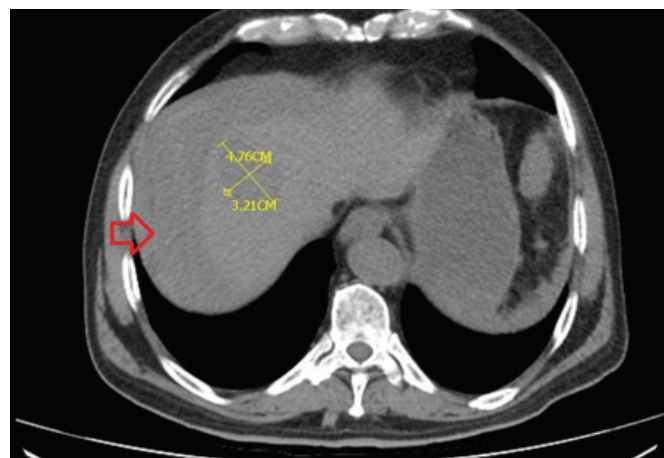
Spontaneous Hepatocellular carcinoma rupture in the abdominal CT (Red Arrow: HCC, Black Arrow: Ascites and hematoma line)
